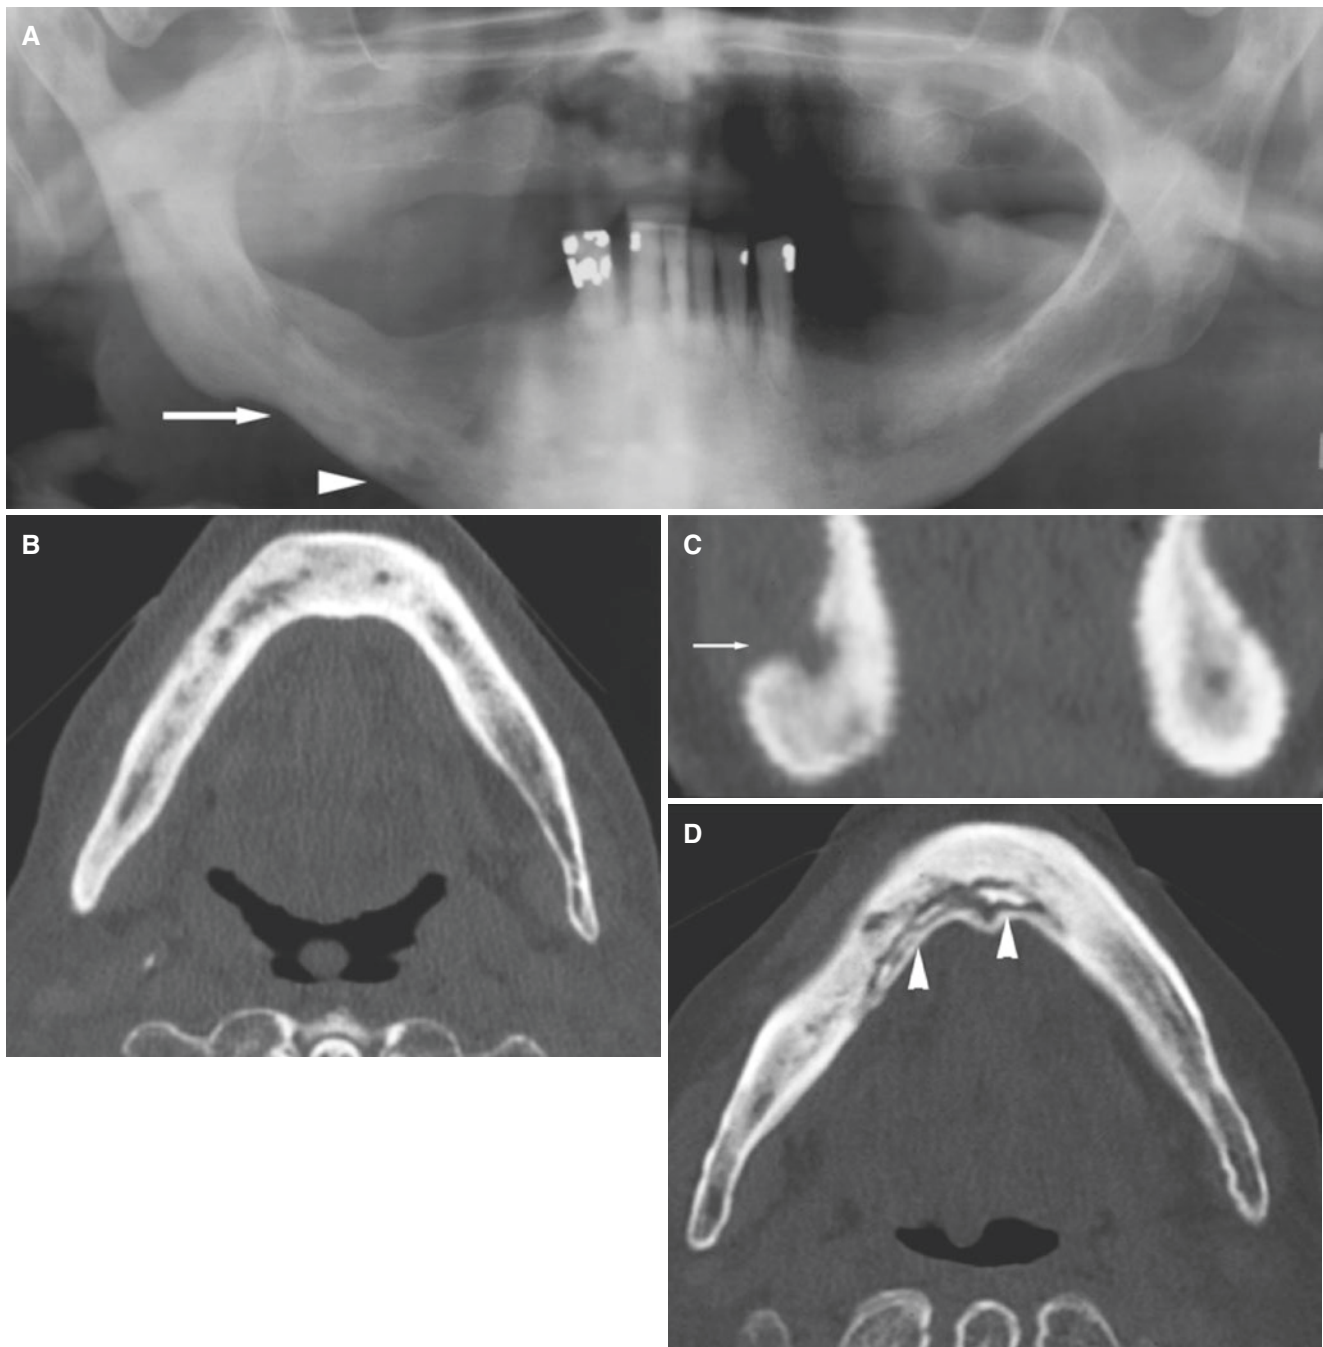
Osteomyelitis, mandible; 72-year-old female with variable but little pain and variable swelling 3 years after teeth extraction, now with mental nerve paresthesia. (A) Panoramic view shows diffuse sclerotic changes (*arrow*) and small focus of bone destruction (*arrowhead*). (B) Axial CT image shows diffuse, extensive sclerotic changes in right
